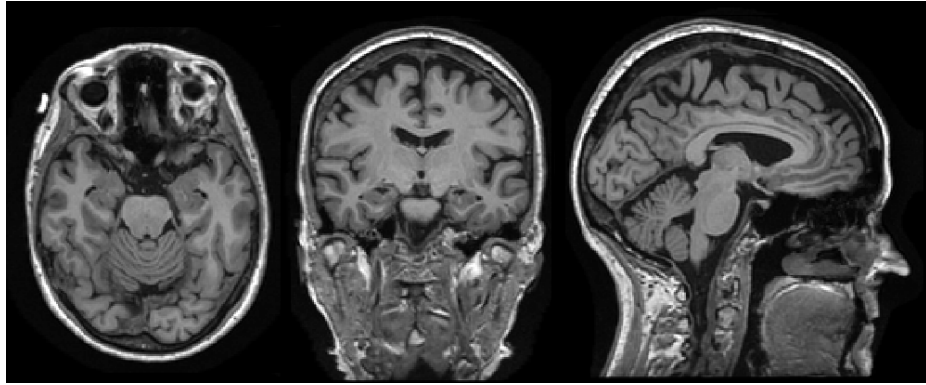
An example of Alzheimer's Disease patient. From left to right: axial slice, coronal slice, sagittal slice of the T1 weighted MRI scan.
